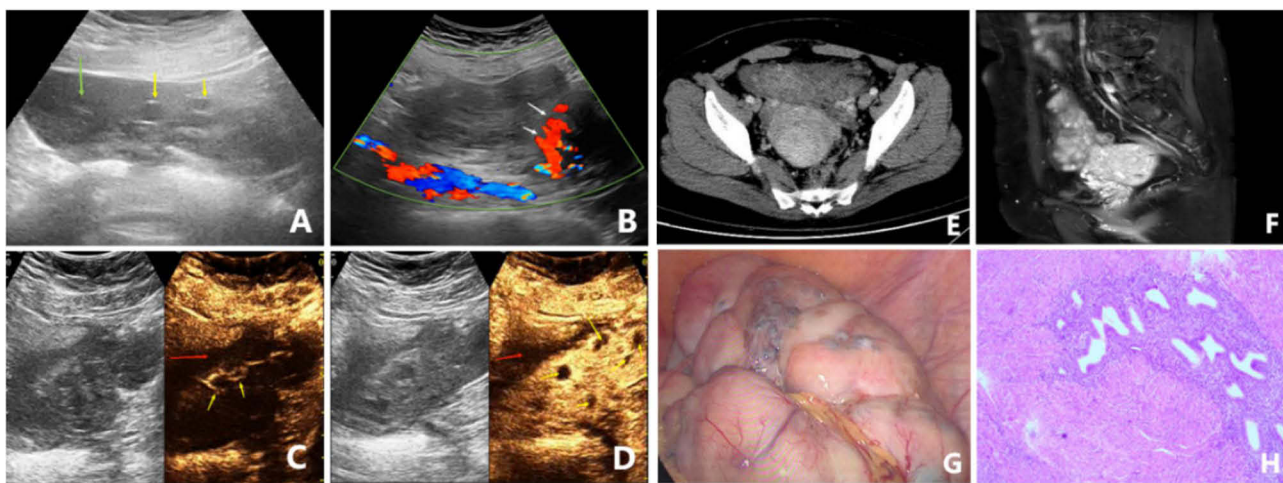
(A) Multiple circular anechoic areas (yellow arrows) are observed within the lump, with hypoechoic areas seen around the periphery (green arrows); (B) Coarse, branch-like blood flow signals are visible both around and within the mass (white arrows); (C and D) Following the injection of contrast medium, the mass enhances in a “vesicle-like” pattern from the center (yellow arrow). The remaining parenchyma shows uniform and equal enhancement, peaking at 25 seconds. Numerous regular, circular non-perfusion areas are visible inside, and a “black margin” of fibrosis (red arrow) is seen at the periphery. Enhancement gradually subsides evenly and slowly by two minutes and 14 seconds. At two minutes and 30 seconds during the regression phase, thick, straight blood vessels are visible at the edge of the mass; (E) CT imaging reveals multiple pelvic masses and nodules; (F) MRI shows an intrapelvic cystic solid mass; (G) Intraoperative view of a pinkish-white mass with multiple purple-blue nodules on the surface; (H) Intraoperative pathology reveals a variety of endometrial glands, endometrial stromal cell proliferation, and disordered arrangement. Abbreviations: CT, computed tomography; MRI, magnetic resonance imaging.
